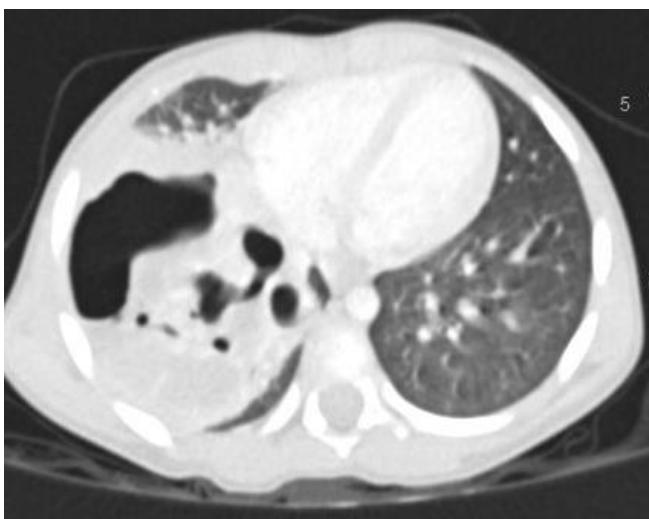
Chest CT scan, axial window showing a large cavity lesion almost occupying the right lower lobe measuring about 63.6 x 76.4 x 46.5 mm with decreased parenchymal enhancement suggestive of necrotizing pneumonia.
